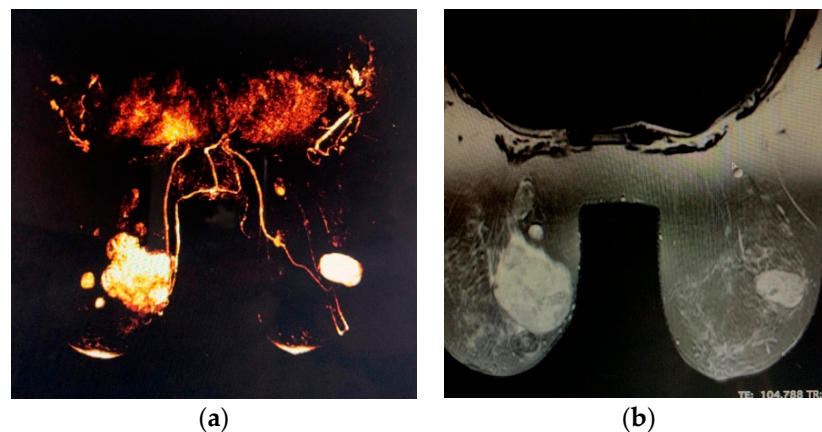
Giant tumor of the breast on magnetic resonance imaging (MRI), (a) three-dimensional (3D) reconstructions for lesion mapping, (b) the giant lesion at the intersections of the inner quadrants of the left breast has an inhomogeneous structure, with hyposignal zones, diffusion restriction and washout areas, and on the lower inner quadrant (LIQ) of the right breast, an area with benign tumor characteristics.
